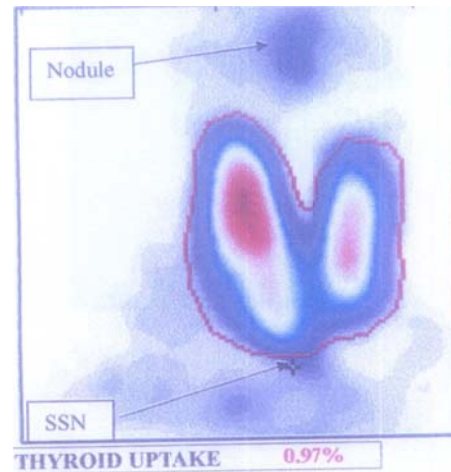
Thyroid scintigraphy showing a normal thyroid gland in addition to radioactive thyroid tissue noted more cranially as an ectopic thyroid tissue as marked by the nodule and another marker point to the suprasternal notch (SSN) and also showing normal thyroid radiotracer uptake (0.97%).
